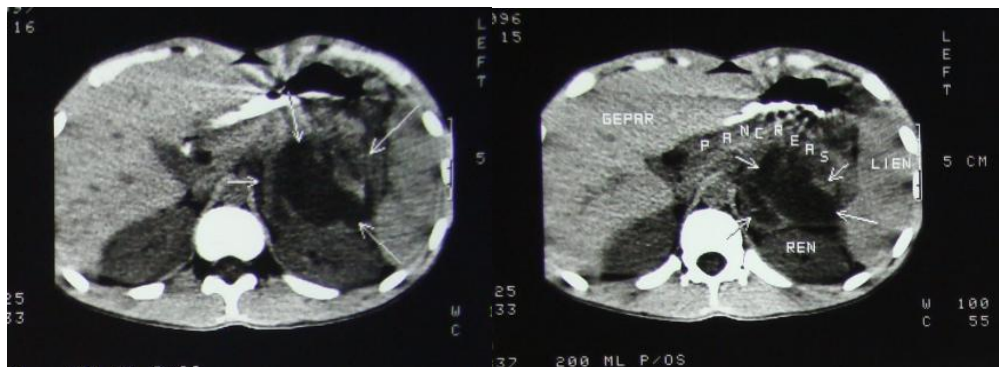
CT of the abdominal cavity. Pseudocyst of the pancreas (arrow).
